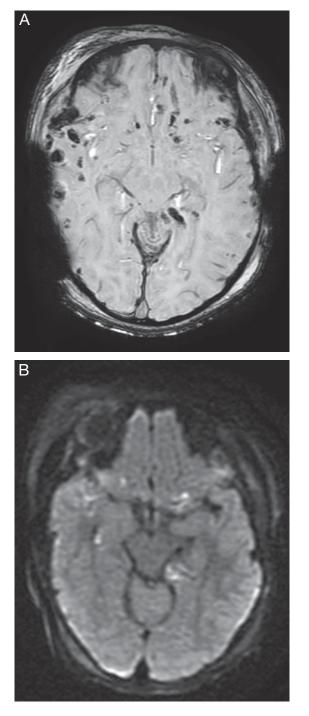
Diffuse Axonal Injury on Magnetic Resonance Imaging.
